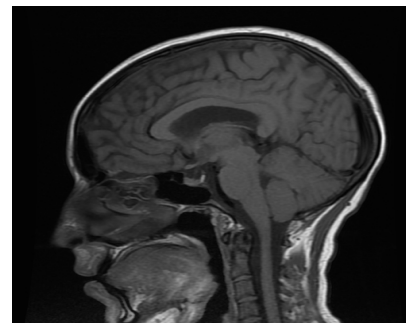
Sagittal T1 sequence of brain MRI showing partial empty sella
